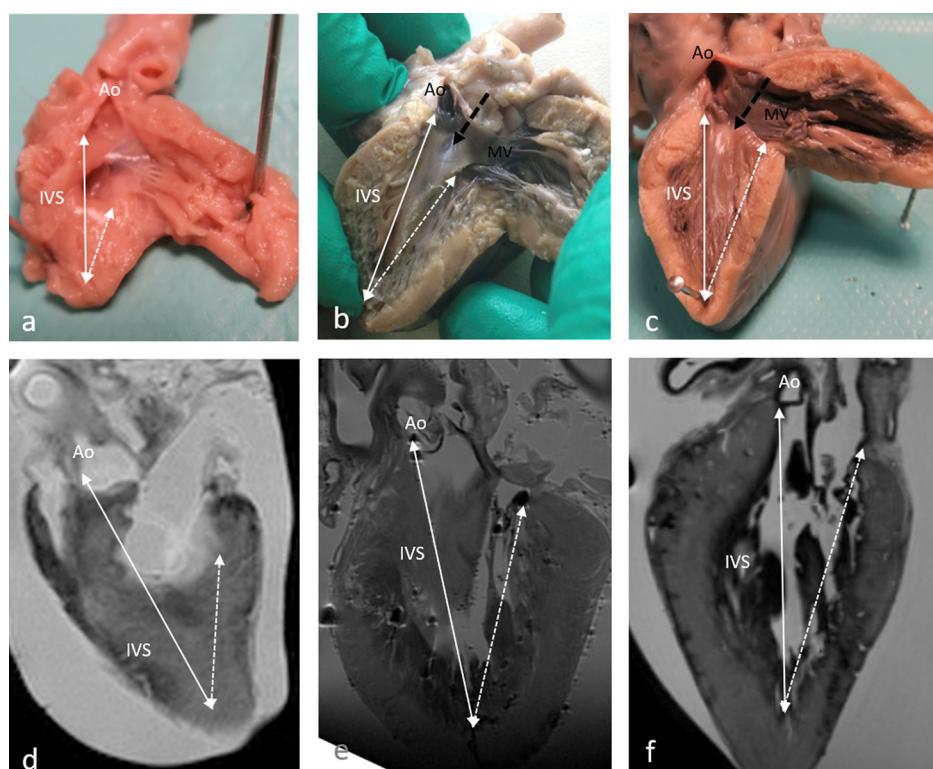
Evaluation of the inlet (dotted arrow)/outlet (arrow) distance ratio on macroscopic dissection and MRI left sagittal views of the interventricular septum in hearts with (a; d) complete atrioventricular septal defect (case 1), (b; e) linear insertion of atrioventricular valves (LIAVV) (case 3) and (c; f) absence of abnormality (case 5). Note the visibility of losangic membranous septum on macroscopic dissection (b) (dotted black arrows) in LIAVV (IVS: interventricular septum, Ao: aorta, MV: mitral valve).
